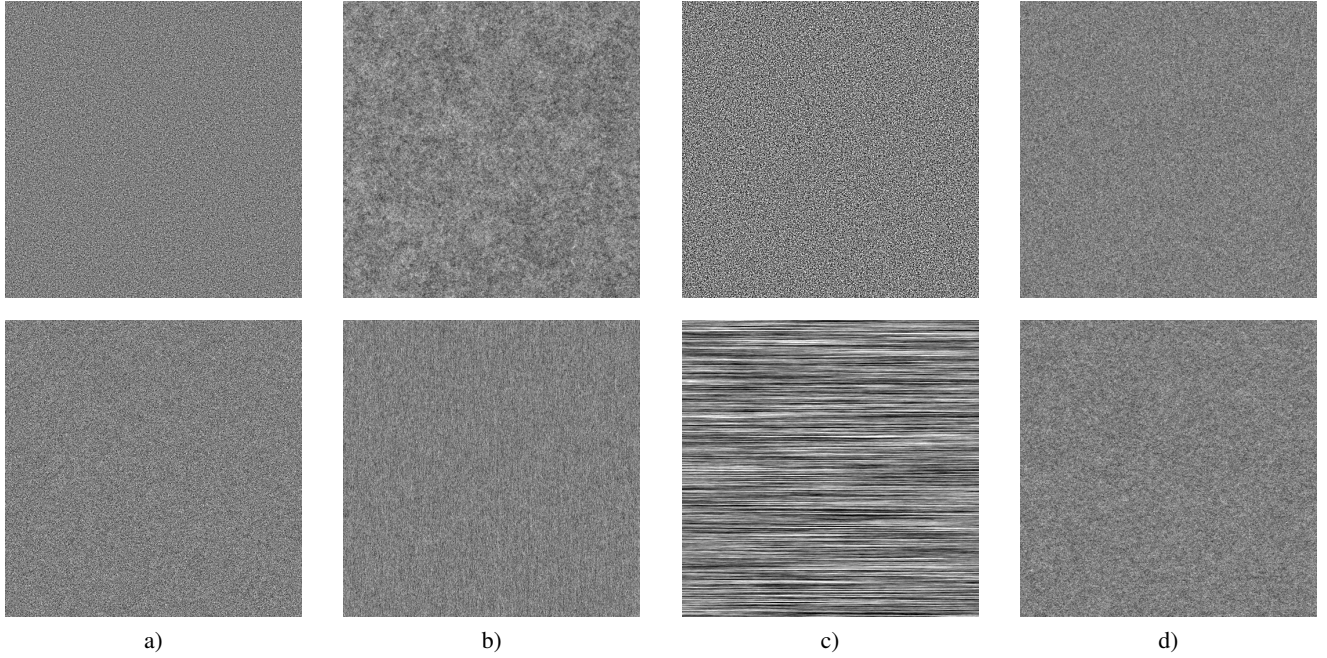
Sample CT noise realizations displayed in arbitrary units, created as described in Section III. Top row: X-Y plane. Bottom row: X-Z plane. a) Non-differential projections. b) Differential (radial). c) Differential (z-direction) d) Differential (both directions). The linear scale is identical all images, except for the noise obtained for differential (z-direction), which was downscaled by a factor of five.
